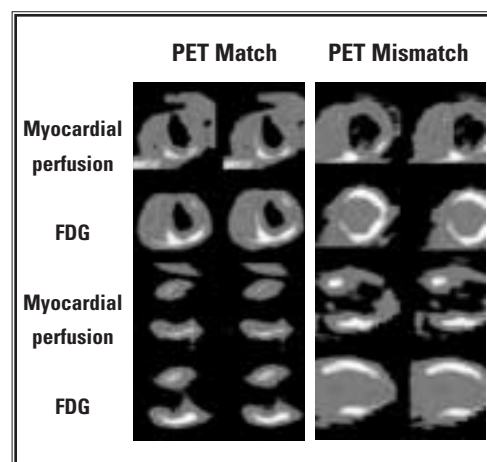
Representative mid-short-axis and vertical long-axis PET images of myocardial blood flow (obtained with N-13 ammonia) and FDG metabolism in patients with prior myocardial infarction. Left: Large and severe perfusion deficit involving anterior, anterolateral, anteroseptal, and apical walls, with a concordant reduction in FDG uptake, consistent with nonviable myocardium (PET match). Right: Similarly large and severe perfusion deficit with relatively preserved FDG uptake, consistent with viable but hibernating myocardium (PET mismatch).
